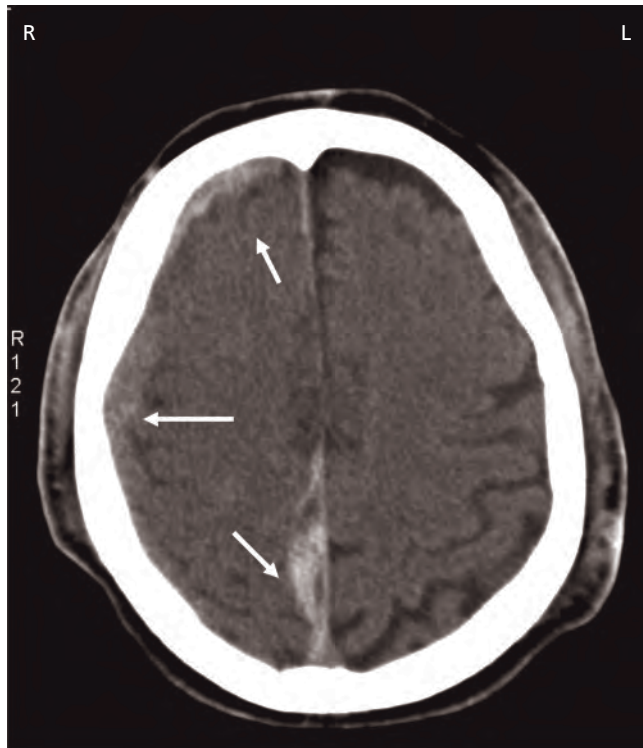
CT scan showing traumatic subarachnoid haemorrhage. Arrows show right anterior and lateral subdural blood collections and parafalcine subarachnoid collection.
